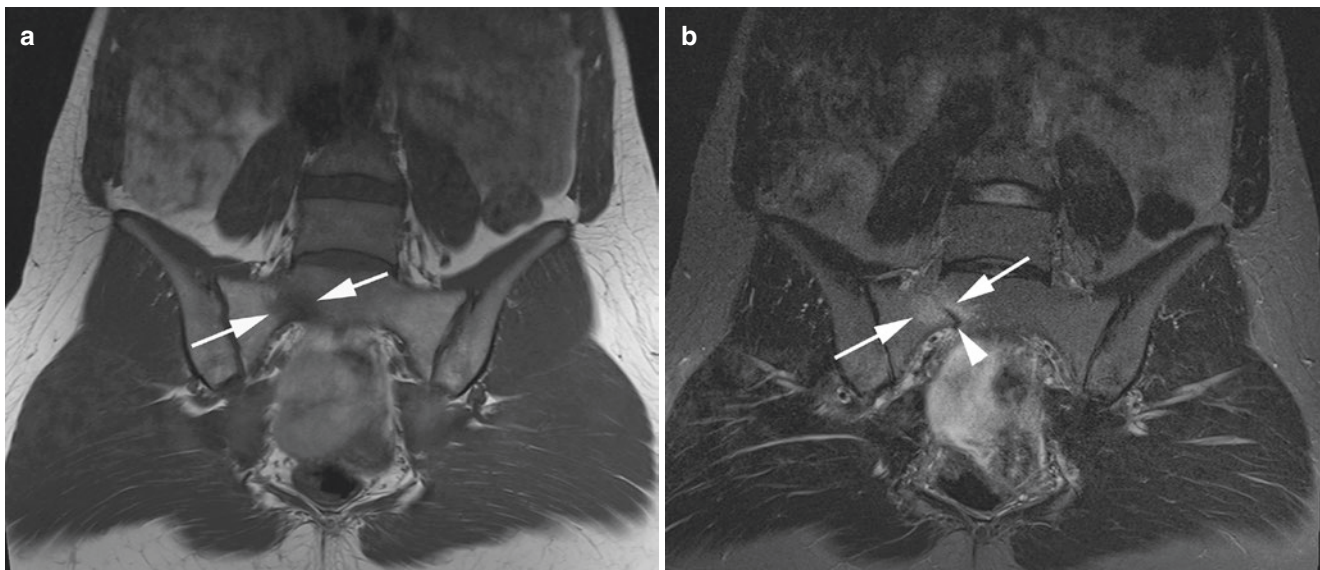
Stress fracture. A 24-year-old male recreational athlete with subacute low back pain. Coronal (a) T1 and (b) T2FS MR images show right-sided focal sacral bone marrow edema (arrows) and fracture line (arrowhead)
